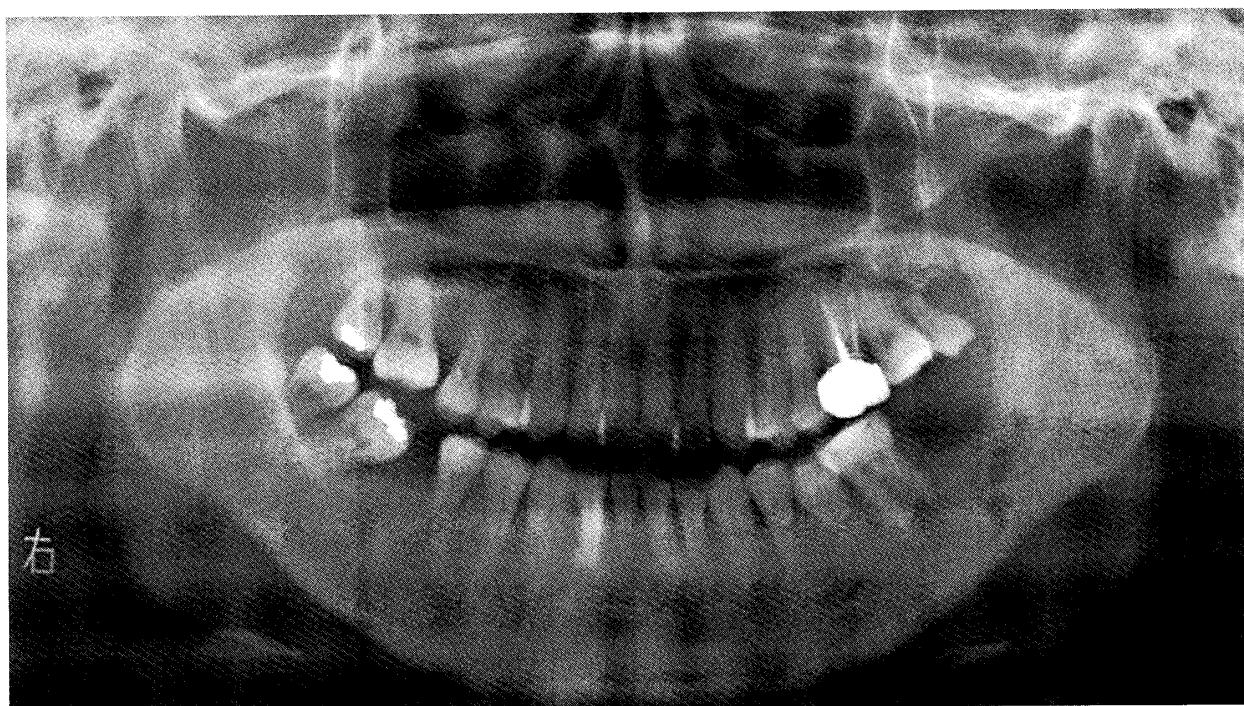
Panoramic radiography at the first examination. A panoramic radiography showed bone resorption with irregular borders mostly around the extraction socket and from first molar to the mandibular ramus, and resorption reached the inferior margin of the mandible in the some areas.
